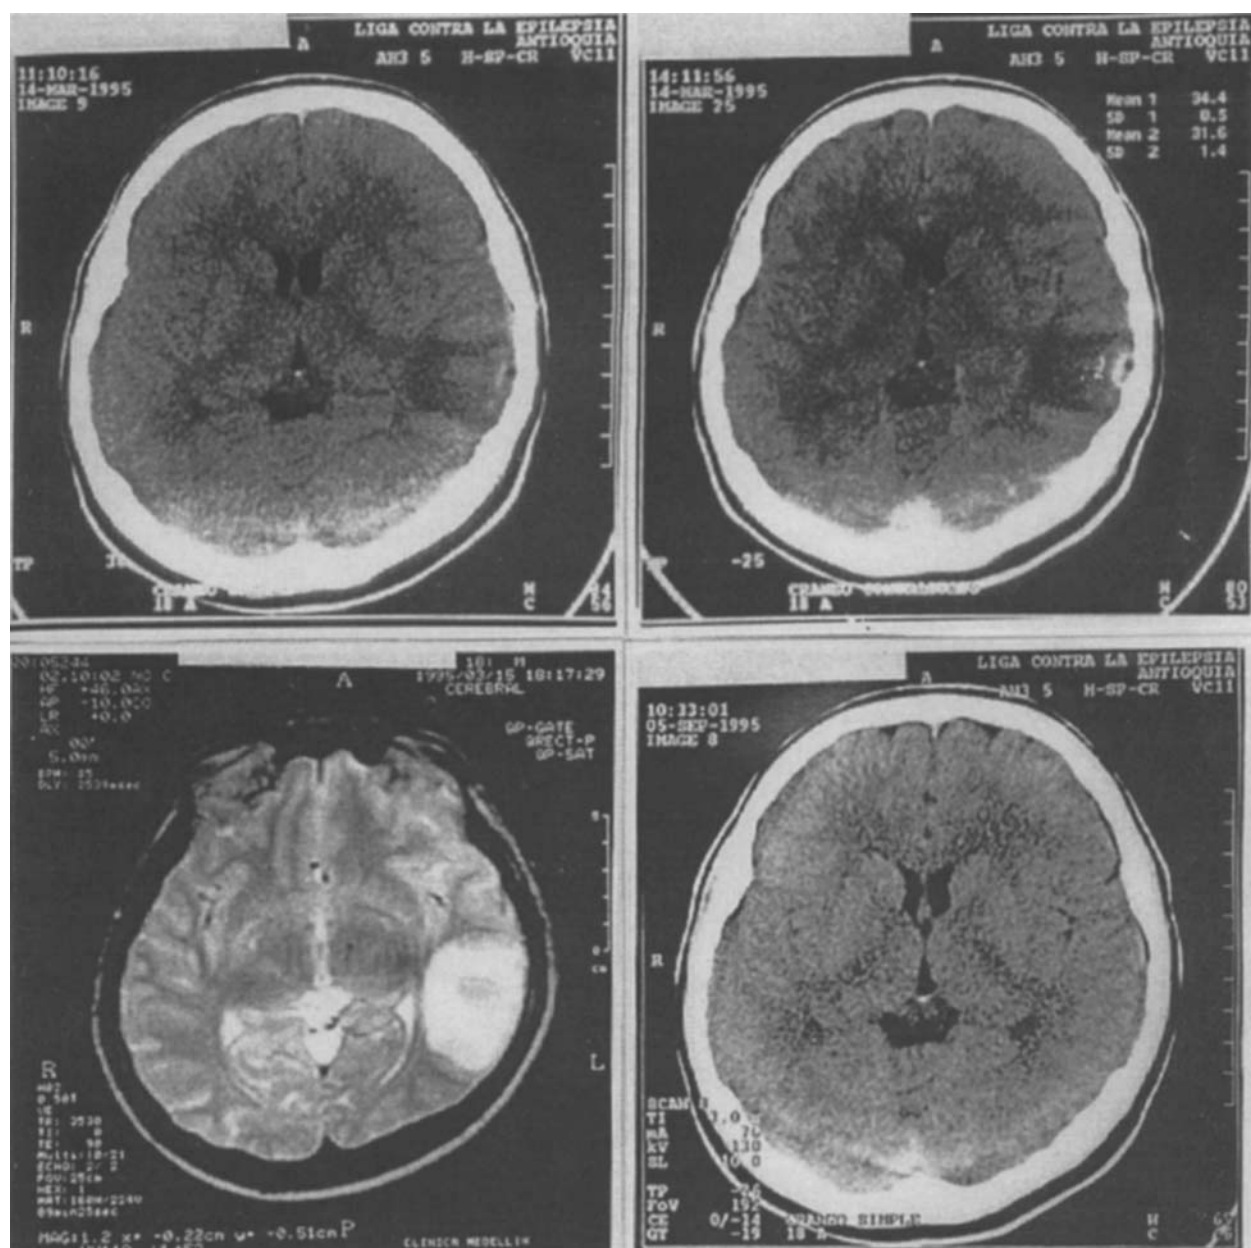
Radiograph of a patient with suspected cysticercosis. The biopsy result of the cyst was inconclusive. EITB test for cysticercosis was positive. Pre- (upper left) and postcontrast (upper right) computed tomography (CT) scan, and T_2 magnetic resonance imaging (MRI; bottom left), showing a degenerating cysticerci in the left hemisphere. The lesion resolved without treatment (bottom right).
